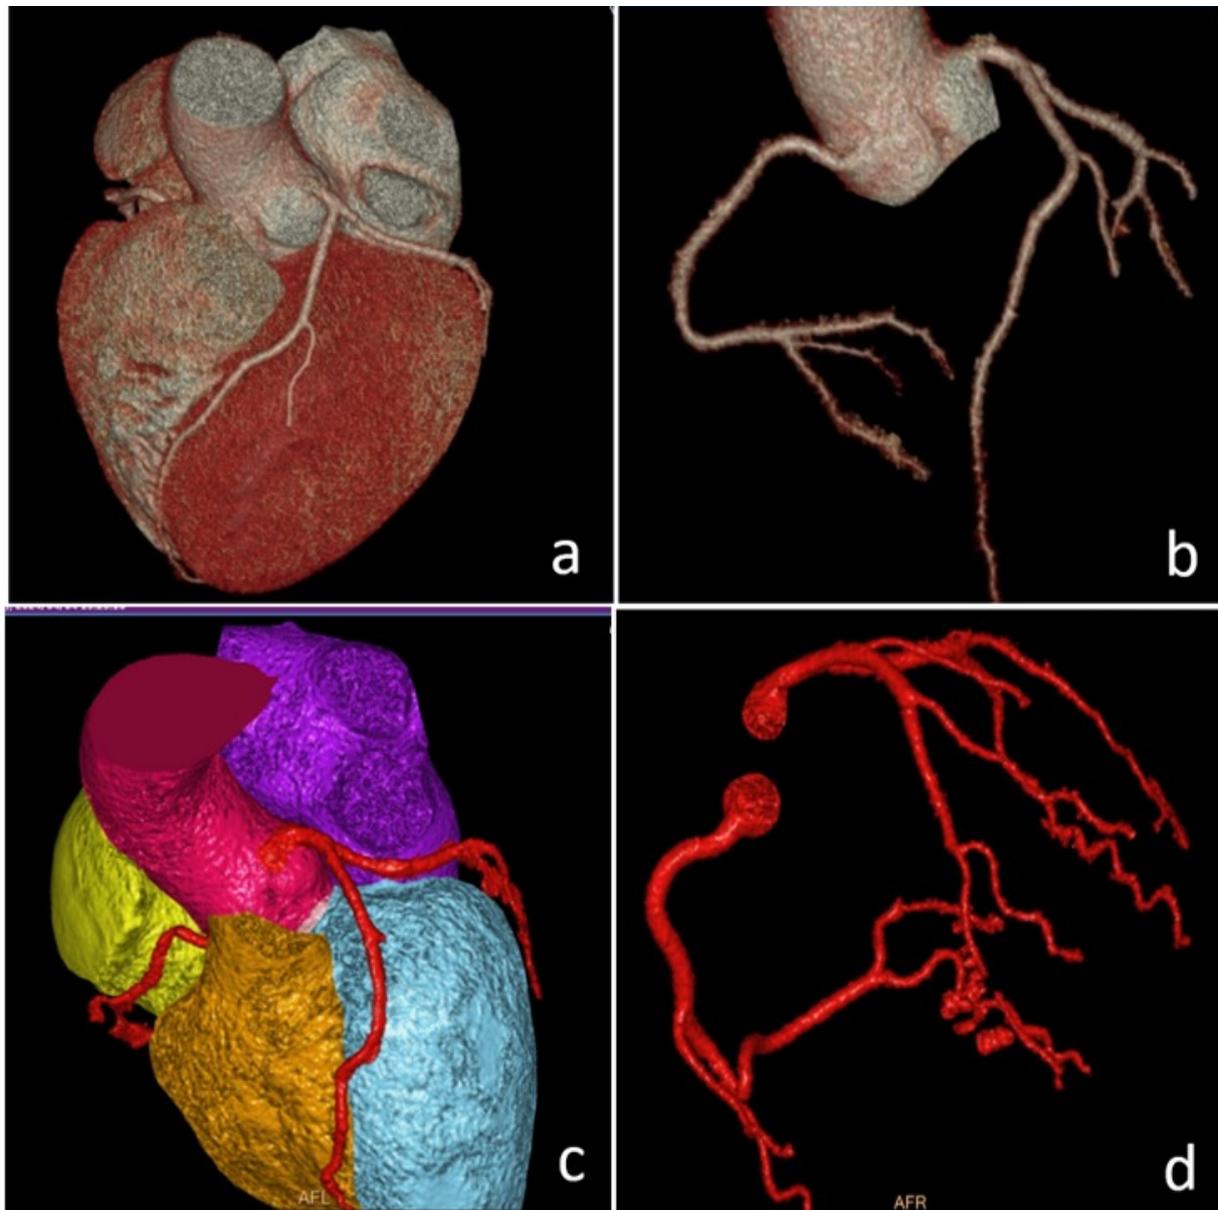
Overview of the post-processing images on Coronary CTA, (a) 3D VRT whole heart, (b) 3D VRT coronary artery tree, (c) Color map 3D-VRT whole heart, (d) Color map VRT coronary artery tree.
